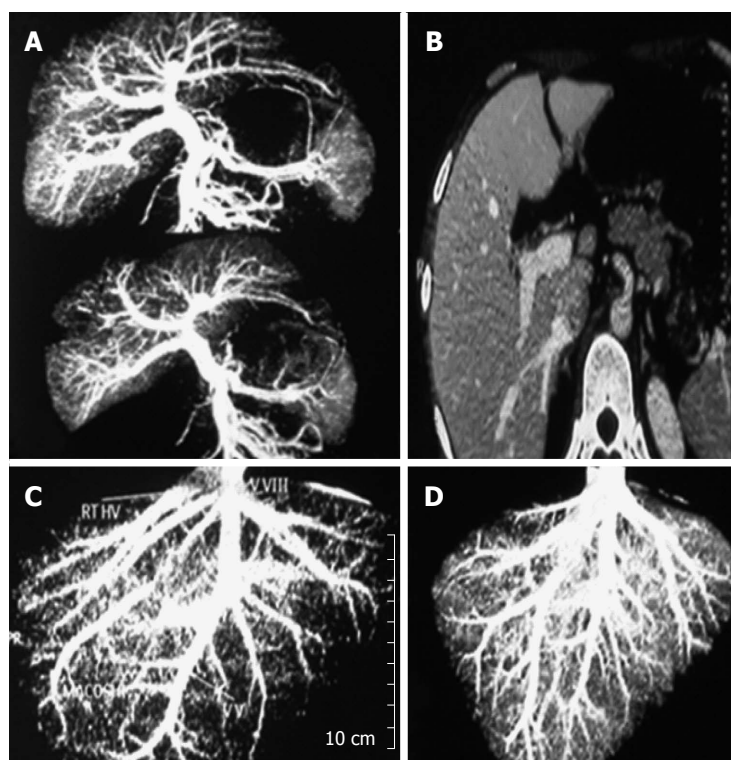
Examples of excluded donors due to unsuitable anatomical variations as shown by imaging studies. (A) Computerized tomographic (CT) portography showing the right portal vein arises from the left portal vein (B) CT volumetry showing that drainage of right lobe is mainly through the middle hepatic vein (C) CT venography showing drainage of the right lobe through multiple hepatic veins (D) CT venography showing small right hepatic vein and inferior right hepatic vein draining into the middle hepatic vein.
